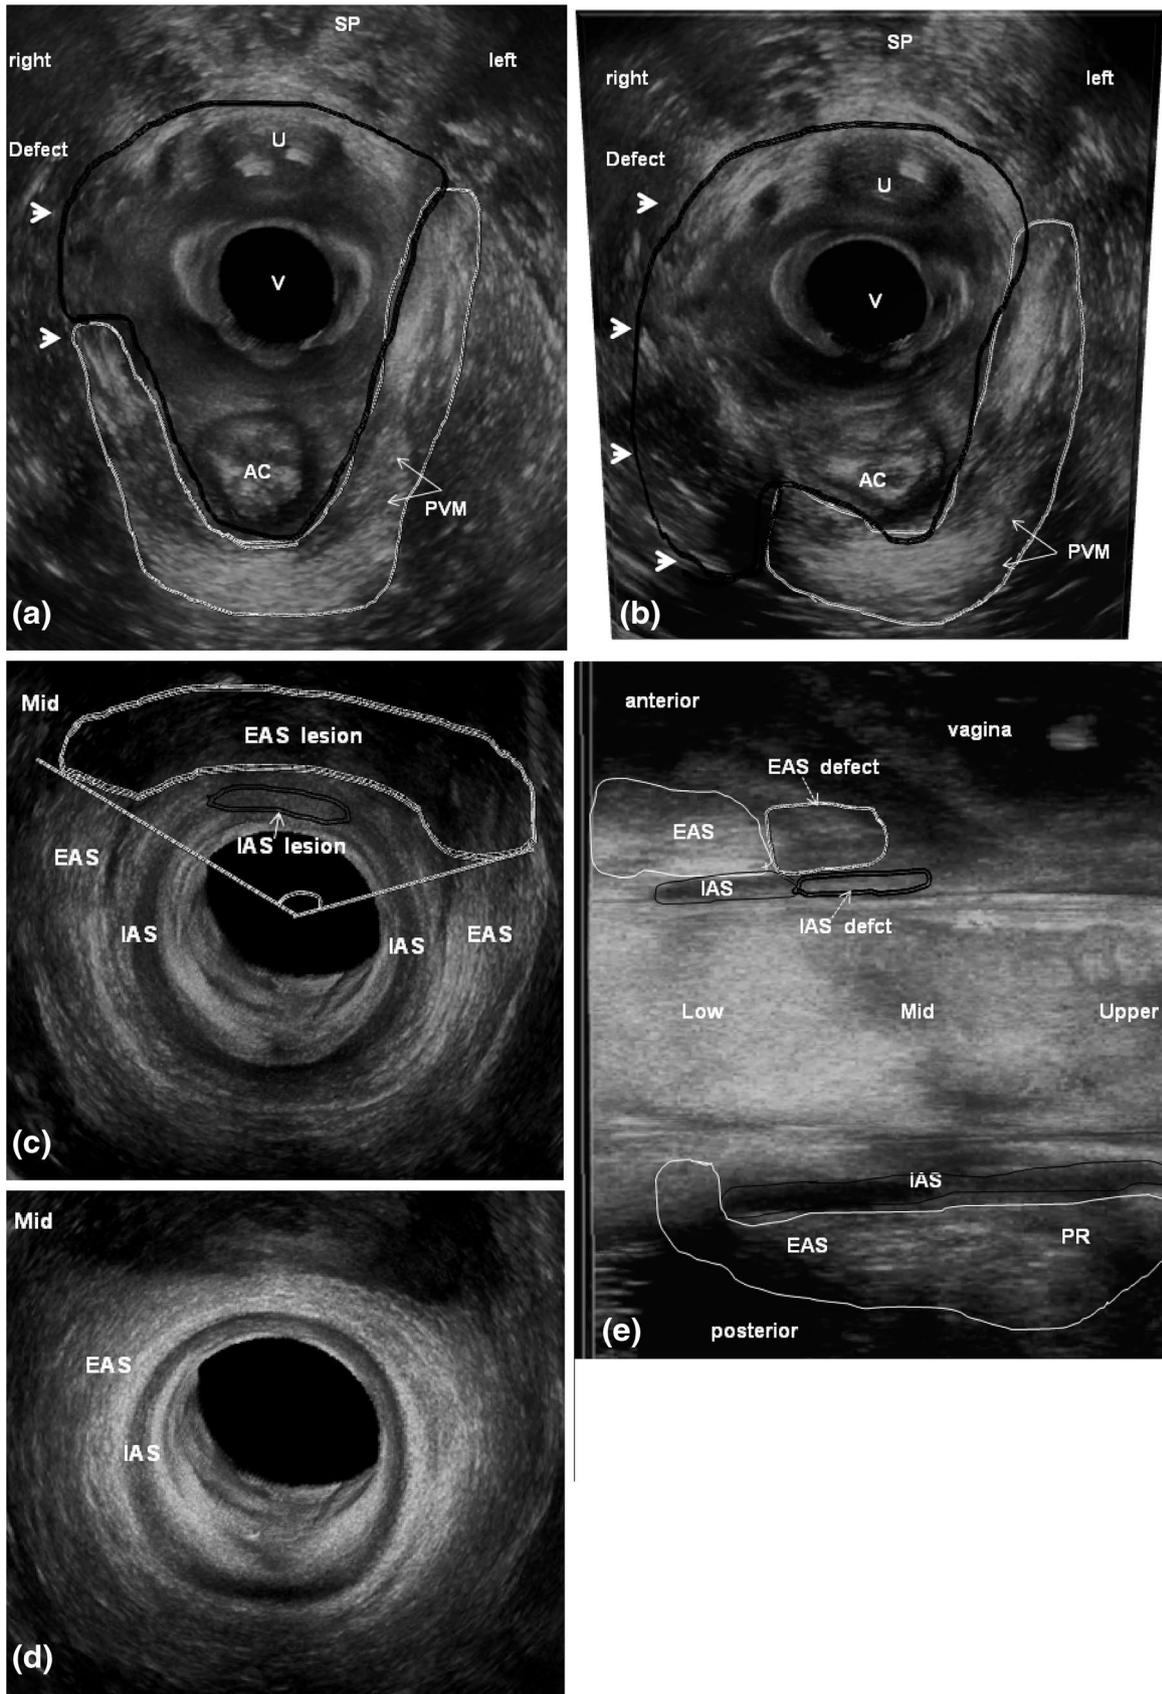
3D-ultrasound—patient with unilateral pubovisceral muscle defect and combined partial external and internal anal sphincter defects after vaginal delivery (render-mode). a Endovaginal approach showing right lateral pubovisceral muscle defect (arrows head) and area of the levator hiatus at rest (black drawn) (axial plane). b Endovaginal approach—increased area of the levator hiatus in the Valsalva maneuver (black drawn). c Anorectal approach showing combined sphincter muscle defects in the anterior quadrant and angle of the external anal sphincter defect in the mid anal canal (axial plane). d Anorectal approach showing intact sphincter muscles in the distal part of the mid anal canal (axial plane). e Anorectal approach showing combined sphincter muscle defects and residual external and internal anal sphincter length (sagittal plane). *U* urethra, *V* vagina, *AC* anal canal, *PMV* pubovisceral muscles, *SP* symphysis pubis, *EAS* external anal sphincter, *IAS* internal anal sphincter, *PR* puborectalis muscle
